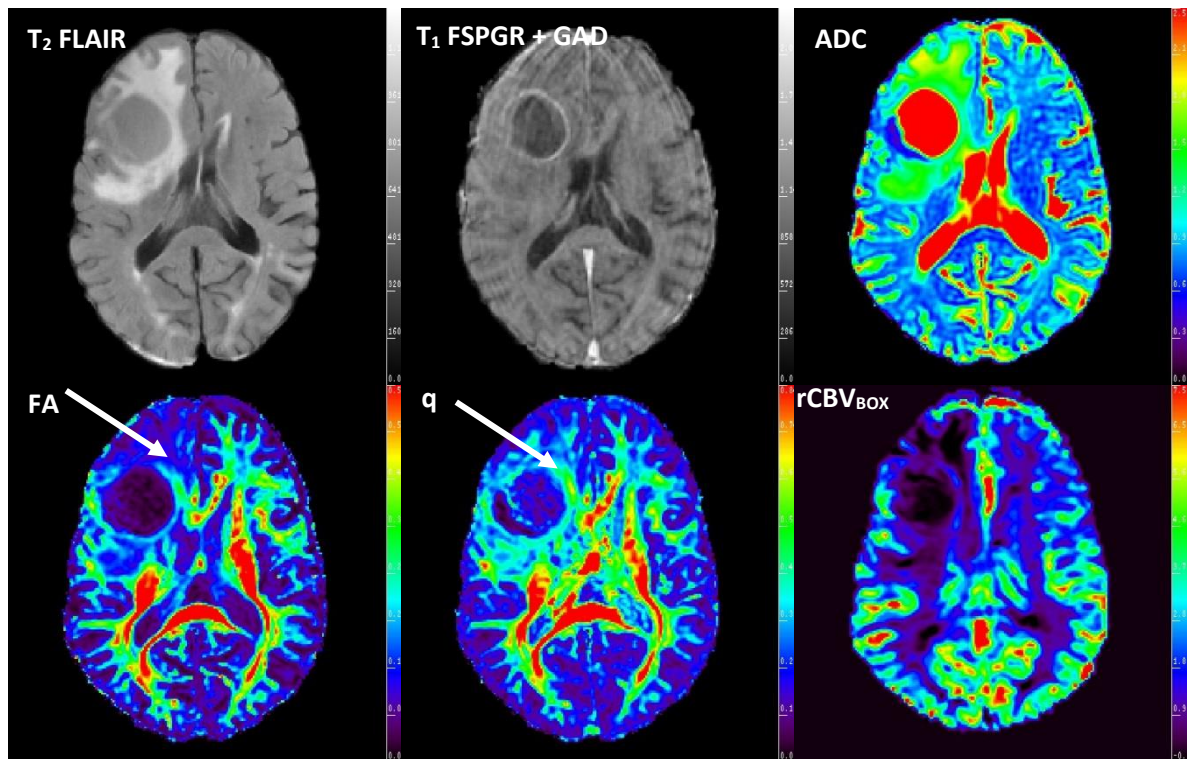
From top right to bottom left, T<sub>2</sub> FLAIR, T<sub>1</sub> post-contrast, ADC  $0-2.5 \times 10^{-3} \text{mm}^2 \text{s}^{-1}$ , FA  $0-0.6$ ,  $q$   $0-0.85$  and Boxerman rCBV  $0-7.5$ , of a representative slice from a lung metastasis patient. Note the enhancing rim lesion with necrotic core presenting in a similar manner to glioblastoma multiforme. The oedema gives the impression of possible tumour invasion based on the FA map which appears less likely on the  $q$  map suggesting oedema is lowering the FA not infiltrating tumour, which agrees with how metastases grow (expanding rather than invading). Metastases are also thought to have lower overall perfusion as seen on the DSC CBV map.
